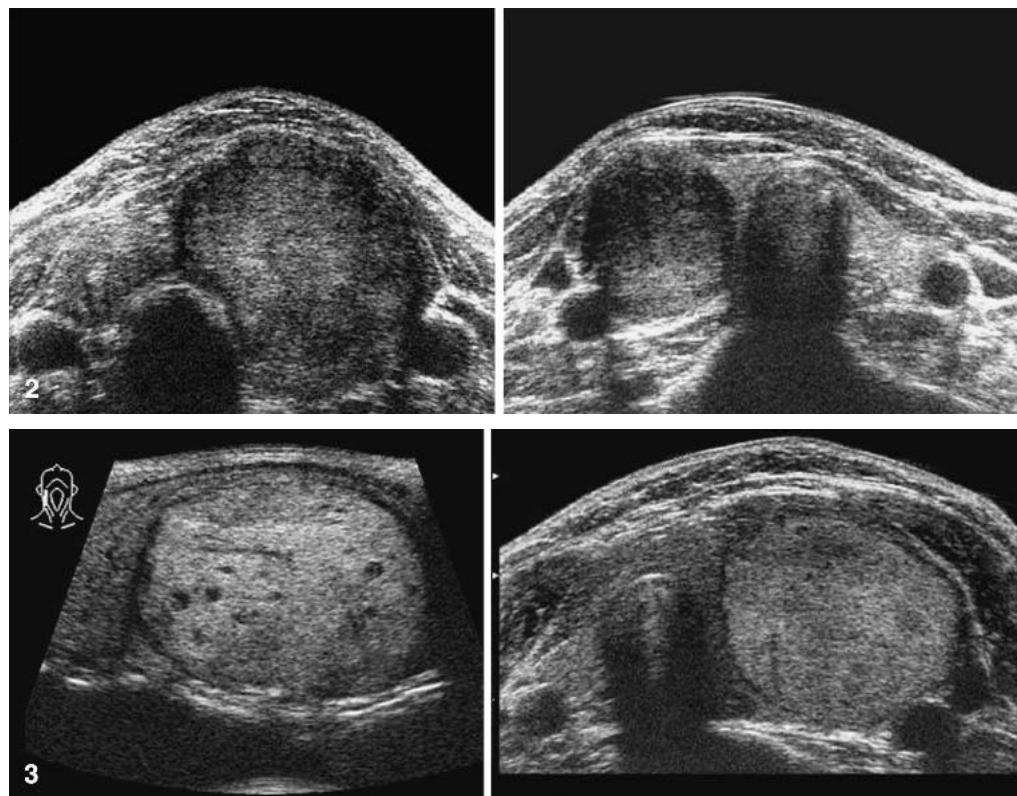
Ultrasonograms of thyroid follicular carcinoma (detectable cases). Left. irregularly shaped solid mass lesion with heterogeneous internal echo in left thyroid lobe. Right. round tumor in the right thyroid lobe with low and irregular boundary echogenicity No calcification or cystic degeneration was observed in these cases.
